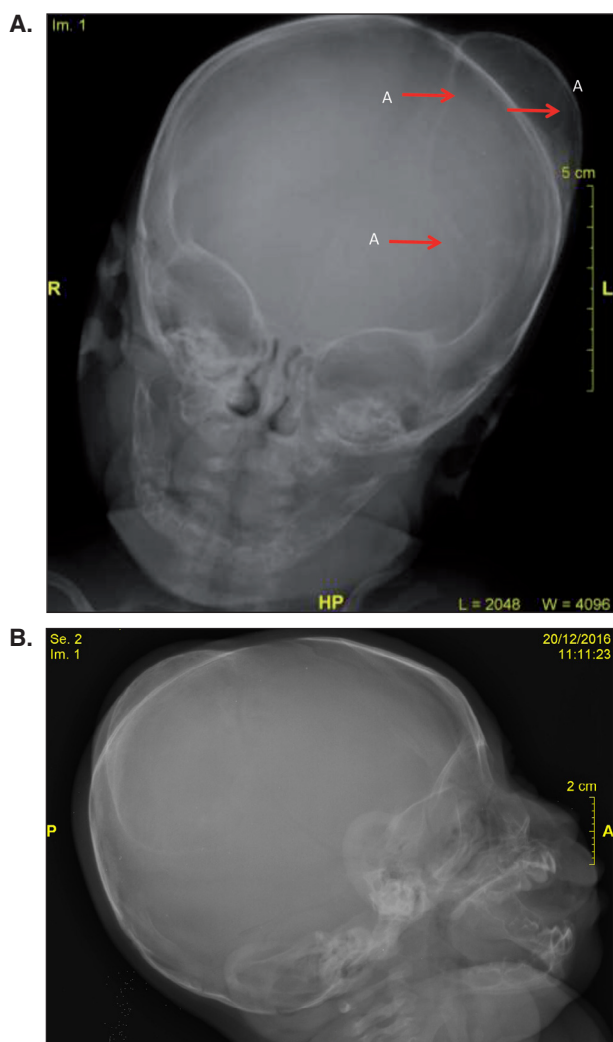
The skull radiograph brought by the mother revealed the characteristic diploe thickening compatible with a calcified cephalohematoma. A. Diploe thickening.
